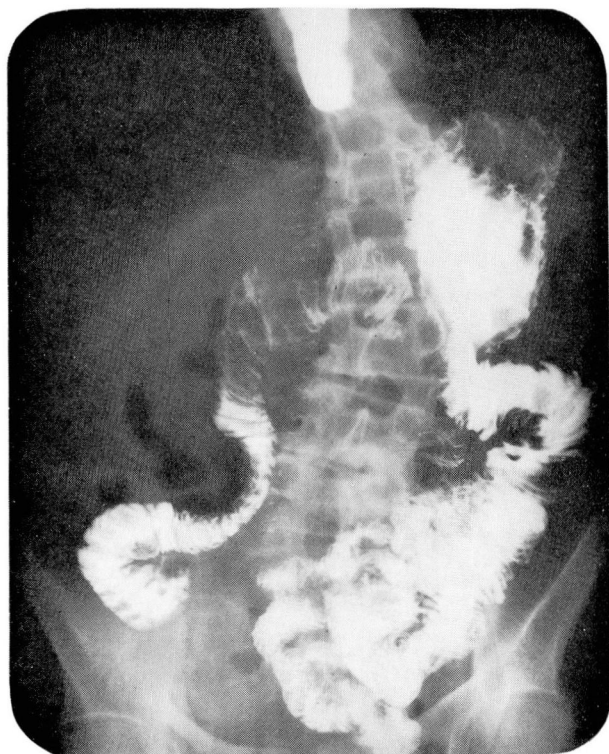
A roentgenogram from a normal gastrointestinal series obtained in November 1966. This study was made after repeated episodes of vomiting, which were attributed to bile gastritis and psychogenic reaction.
